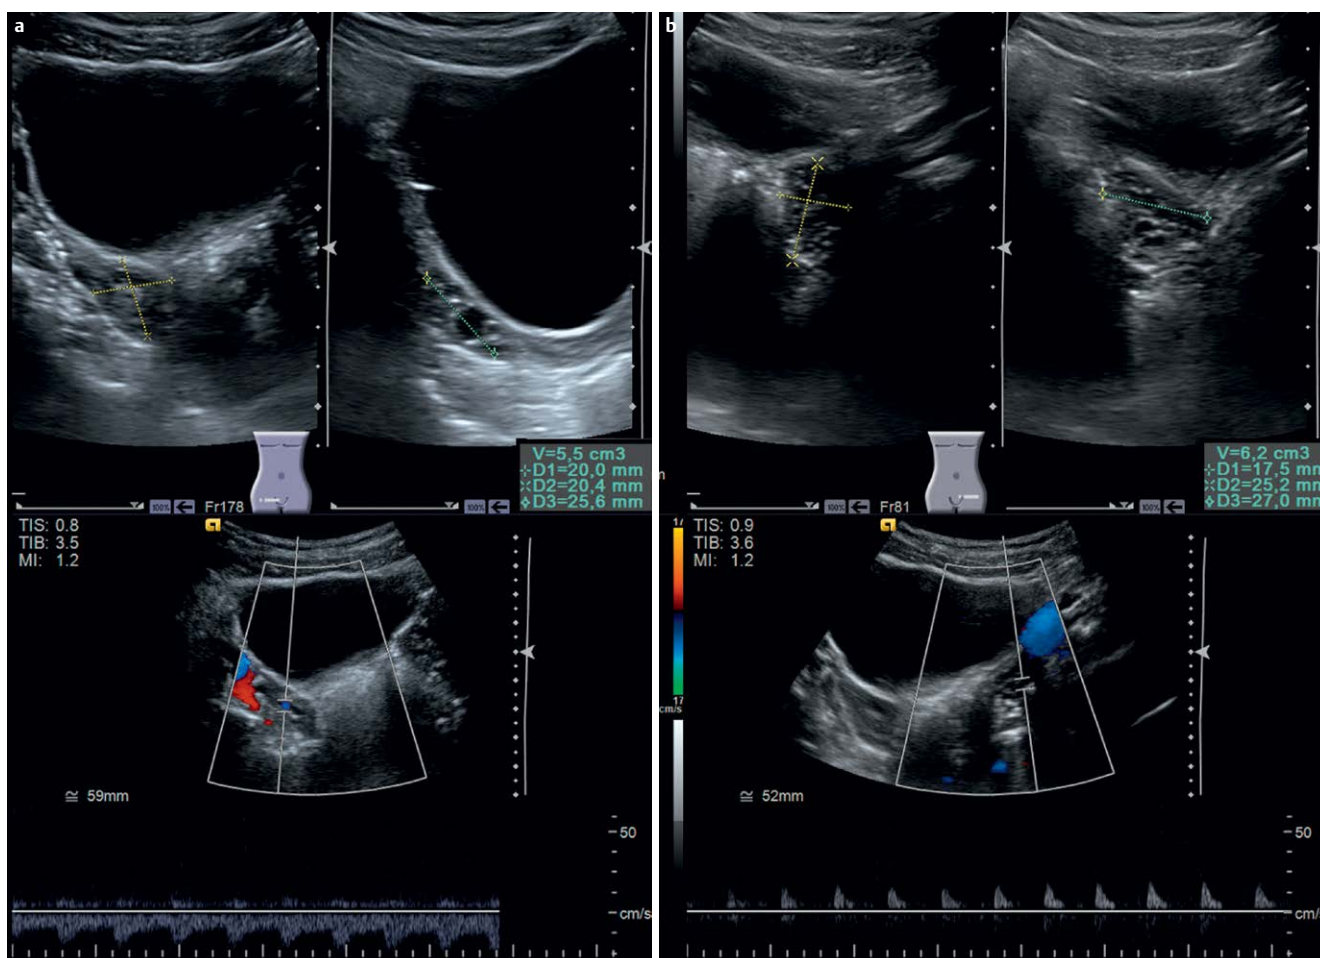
a 5 months after surgery, the follow-up sonography shows a marked decrease of the ovarian size (5.5 ml) on the right side. b The size of the left ovary is now similar to the right ovary. The Doppler flow pattern of the right ovary is postpubertal, while the flow pattern on the left side is still prepubertal.
